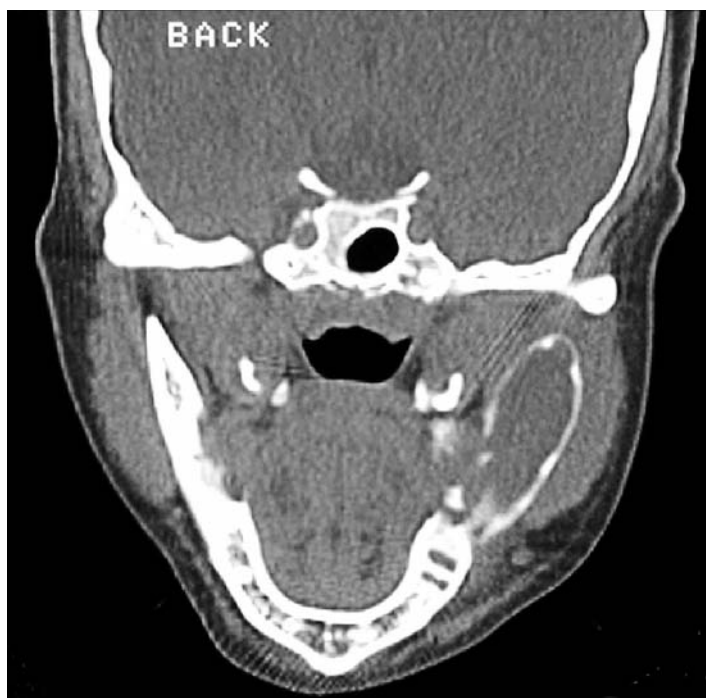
CT scan of the mandible showing buccal and lingual expansion on the left side, with thinning and perforation of the lingual plate. (Courtesy of Dr R. Hendricks.)
